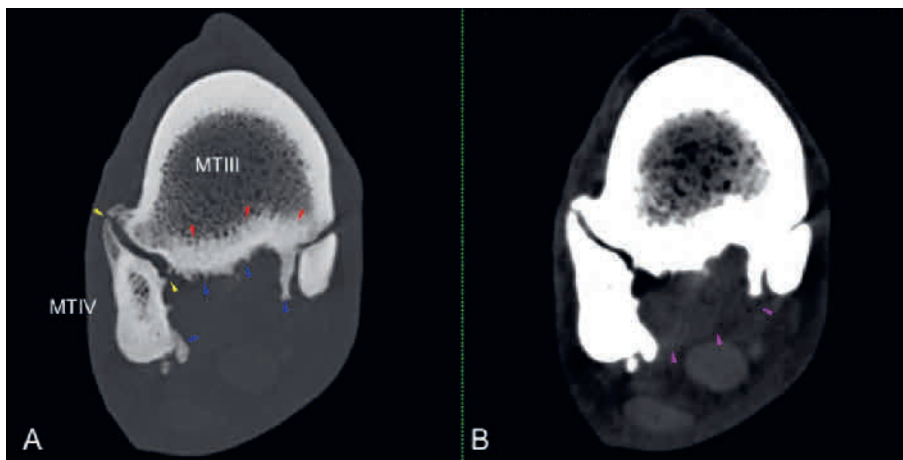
Transverse CT images of the right hind metatarsal region in bone (A) and soft tissue algorithm (B) approximately 1 cm distal to the tarsometatarsal joint. Red arrowheads indicate plantar cortical sclerosis, blue arrows large enthesophytes at the plantar aspect of MTIII, yellow arrows remodeling of the fourth metatarsal bone and bridging bone to the third metatarsal bone and purple arrowheads indicates the thickened SL. | CT-Bild in Transversalebene in Knochen- (A) und Weichteil-Algorithmus (B) ca. 1 cm distal des Tarsometatarsalgelenks. Die roten Pfeile zeigen plantare kortikale Sklerosierungen, die blauen Pfeile große Enthesophyten, die gelben Pfeile Umbauvorgänge am MTIV und Knochenbrücken zum MTIII und die lila Pfeile die kaudale Kontur des verdickten Fesselträgers.
